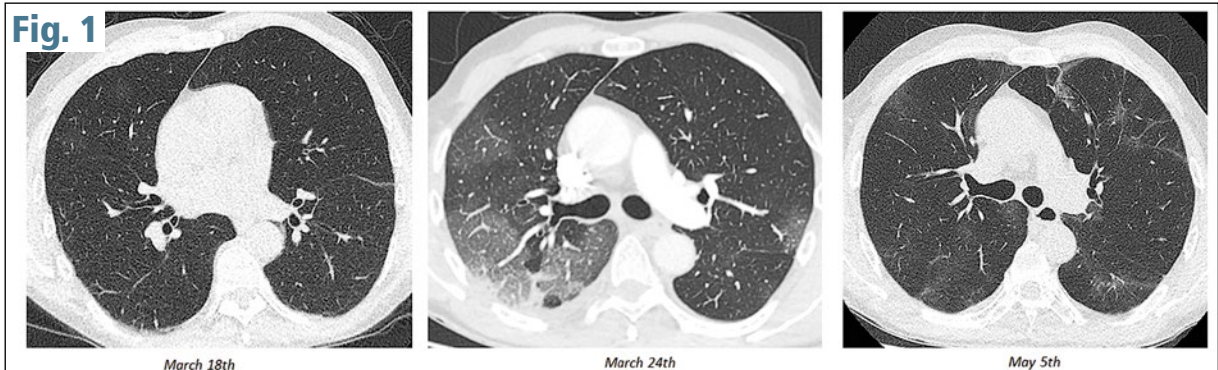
Good evolution of a COVID-19, with almost normal initial chest CT at D3, extensive ground glass opacities (GGO) at D9 and almost complete resolution with limited residual GGO at six weeks
